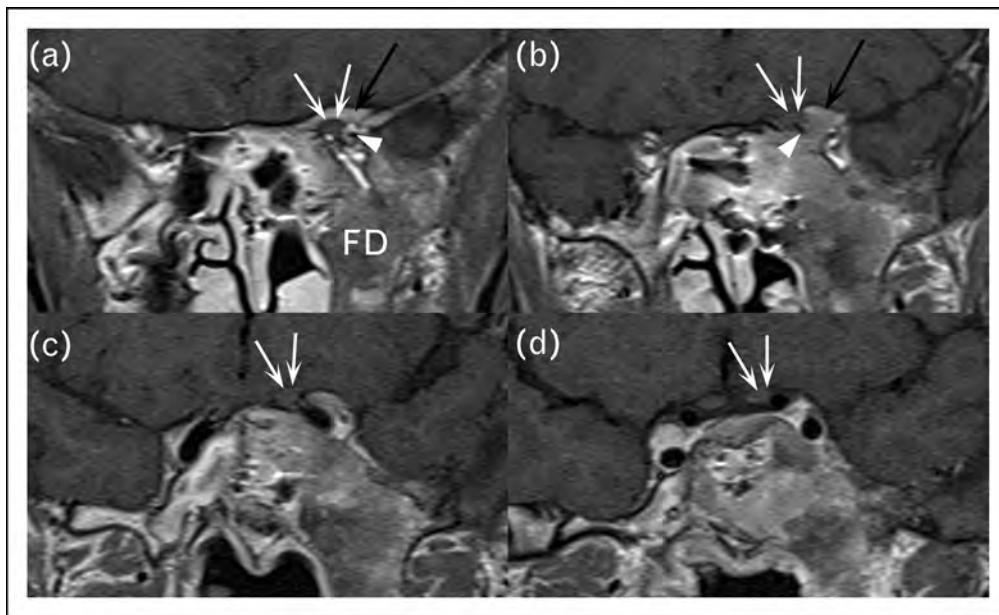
(a–d). Fibrous dysplasia in a 40-year-old men. Magnetic resonance in the coronal plane, T1-weighted image after contrast agent administration. Fibrous dysplasia of left sphenoid bone. In (a) and (b), the left optic nerve (white arrows) and ophthalmic artery (arrowhead) are surrounded by the fibrous dysplasia involving the lesser wing (black arrows), the sphenoid sinus, and pterygoid process (fibrous dysplasia). (c) and (d) show the course of the left optic nerve towards the chiasm. Nonhomogeneous enhancement of fibrous dysplasia is demonstrated after contrast agent administration.
